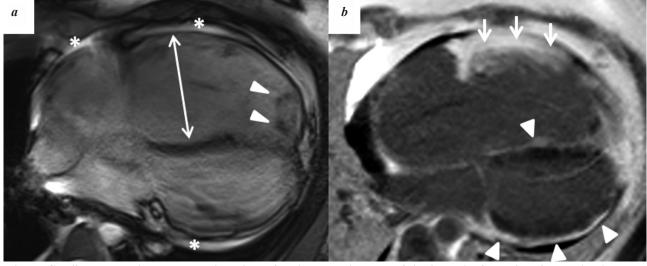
Cardiac magnetic resonance imaging of patient 4m: images of the heart in four-chamber projection in the end-diastolic phase. Cine-image (a): marked dilation of the right ventricular cavity (thin white arrow), thrombus in the right ventricular cavity (white arrow heads), effusion in the pericardial cavity (white asterisks). Delayed contrast enhancement (b): transmural myocardial fibrosis of the lateral wall of the right ventricle (white arrows), subepicardial myocardial fibrosis of the lateral wall of the left ventricle and interventricular septum (white arrow heads).
